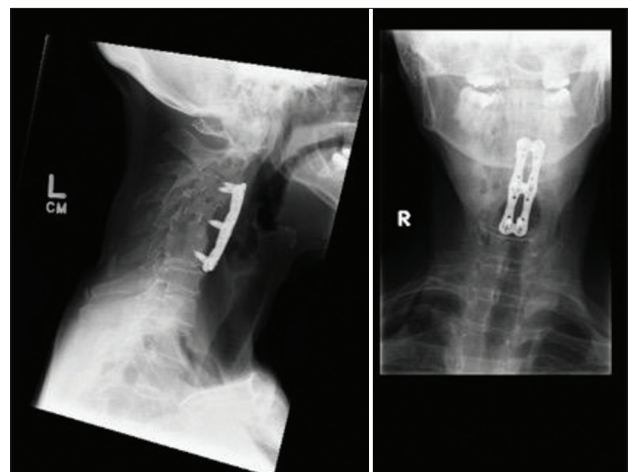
Neck X-rays at 18 months after initial surgery showing some flexion in the mid-cervical spine in the fused segment. The vertebral bodies appear completely fused together and are stable
